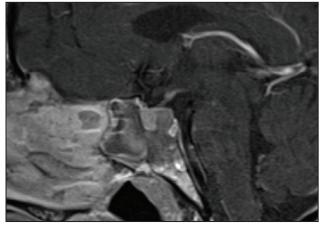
Initial magnetic resonance imaging showing limited enhancement in posterior pituitary and decreased T1 signal in clivus.
